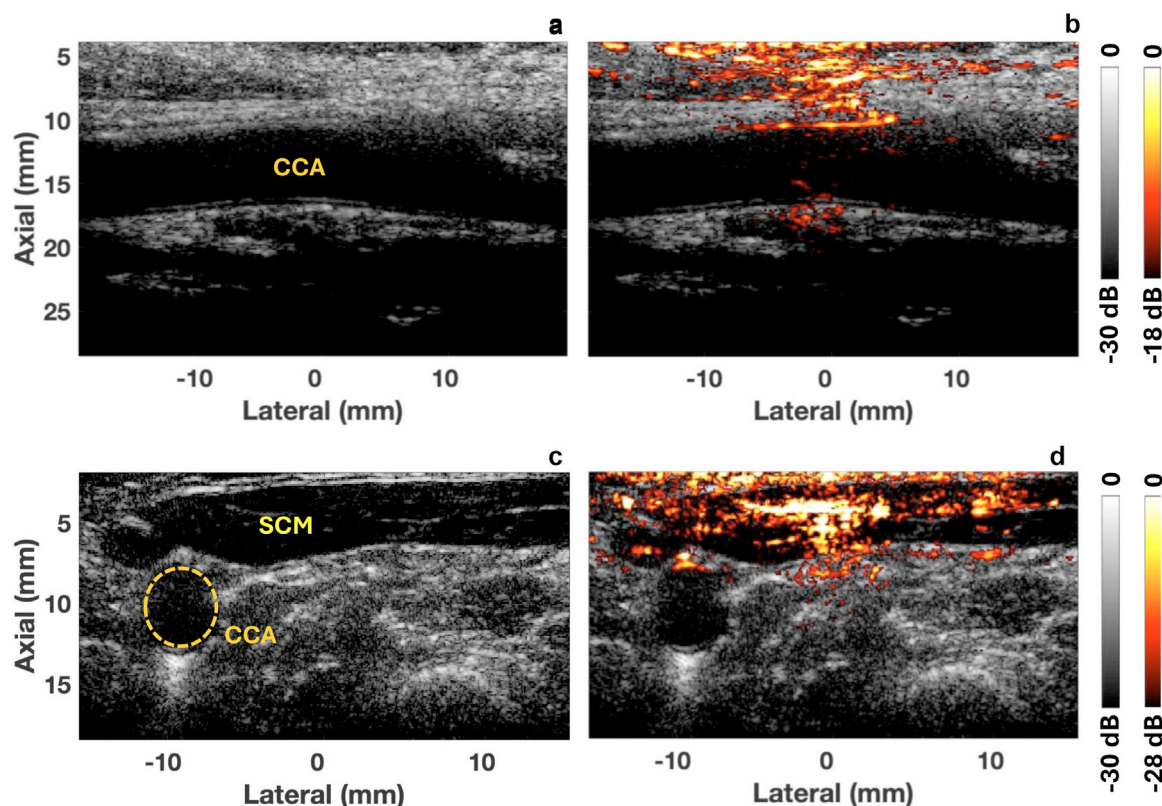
Carotid artery imaging. (a) Longitudinal ultrasound (US) image of the common carotid artery (CCA) and (b) corresponding photoacoustic image overlaid on top of the US image. (c) Cross-sectional US image showing the sternocleidomastoid (SCM) muscle and the CCA and (d) overlaid photoacoustic image. SCM.
